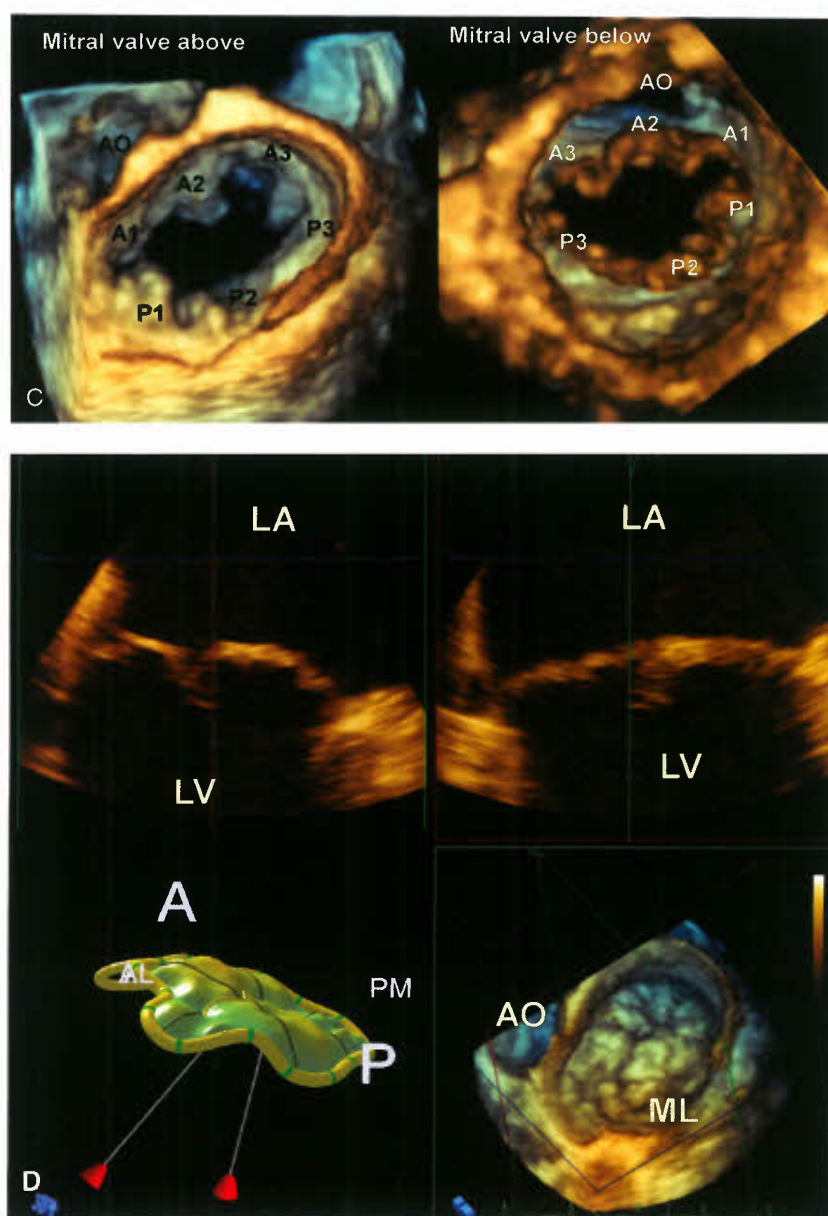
A: This parasternal long-axis view demonstrates the 2-D features of mitral valve prolapse, with part of the anterior leaflet being behind the high point of the mitral annulus (black arrow). LA, left atrium; LV, left ventricle. B: This 3-D image of mitral valve prolapse was taken using transesophageal echocardiography. It is the same case as Figure 45.18A and shows the detail that is possible by this technique. The prolapsing segments of the valve can be seen, with the right hand panel showing the sites of regurgitation. The image with the color Doppler assessment also shows the division of the valve into segments A1-A3 and P1-P3. The mitral valve is viewed from the left atrium. AL, aortic leaflet; AO, aorta; ML, mural leaflet. C: These two images show the mitral valve from above and below, demonstrating the individual scallops of the leaflets, as well as their dysplastic nature and the commissures. AO, aorta; A1, A3, and P1-P3 represent the individual segments of the aortic and mural leaflets and is the nomenclature that is used to describe them for surgical management. D: This series of images is obtained from a MPR format and represents the reconstructed 3-D image as seen in the lower right hand panel, with the 2-D images in the upper two panels, with each being at right angles to each other. The lower left hand panel is a reconstructed image that shows how the relationship of the annulus to the prolapsing segments can be calculated using QLab software. AO, aorta; LA, left atrium; LV, left ventricle; ML, mural leaflet; PM, papillary muscle.
